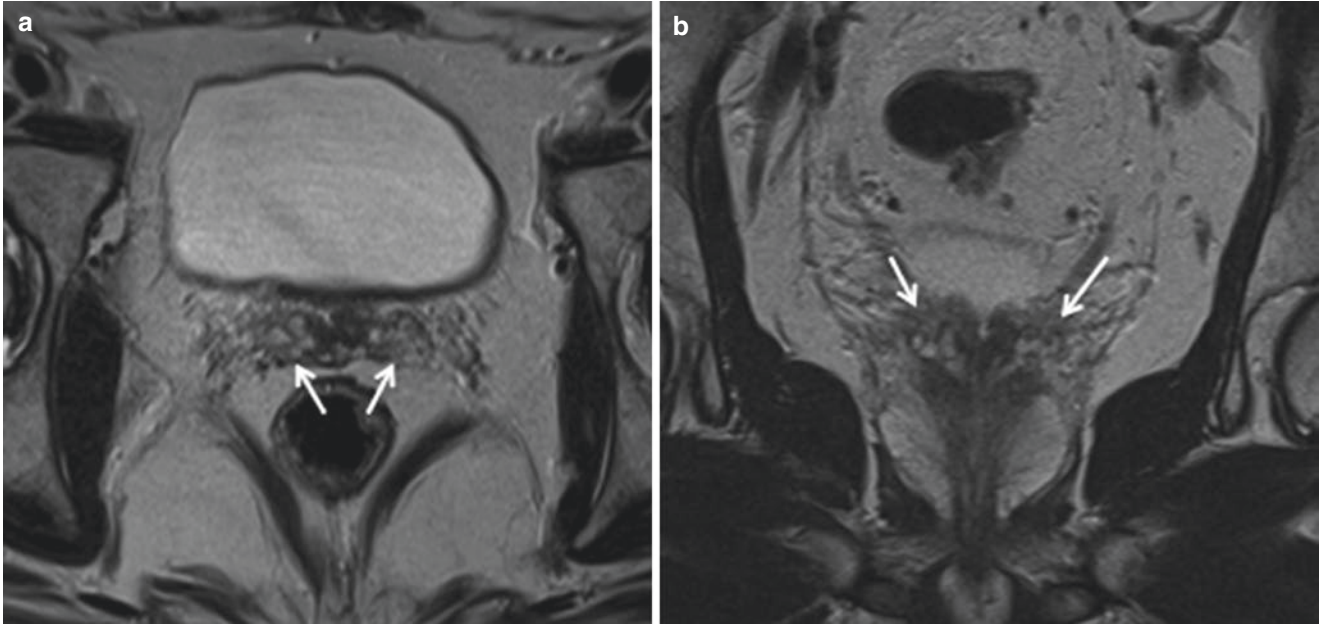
Bilateral SV hypoplasia in a 31-year-old man with infertility. Axial (a) and coronal, (b) T2-weighted MR image shows a bilateral small SV (arrows)
